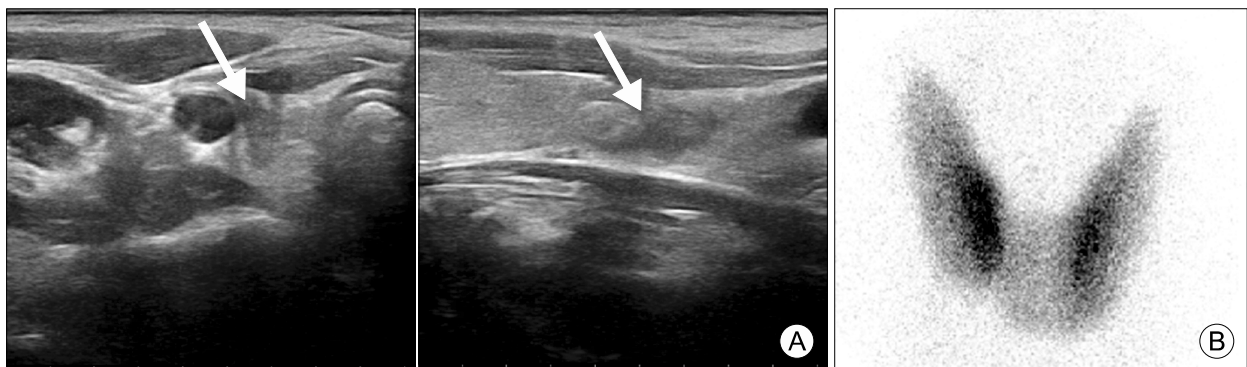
Initial thyroid ultrasonography and 99m-Tc scintiscan. (A) Thyroid ultrasonography showed an ill-defined hypoechoic nodule (1.0×0.5×1.5 cm) in the right lobe of the thyroid gland (indicated by white arrows). (B) Thyroid scintigraphy with 99m-Tc revealed normal radiotracer uptake in the thyroid gland.
